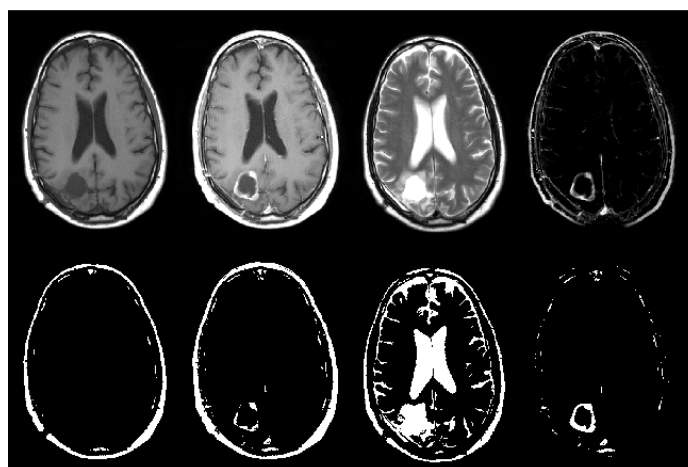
Thresholding results on one slice from different MRI sequences. On the top row from left to right: T1, T1C, T2, T1C-T1. On the bottom row from left to right, the thresholding results for th_2 over the respective modality above.
